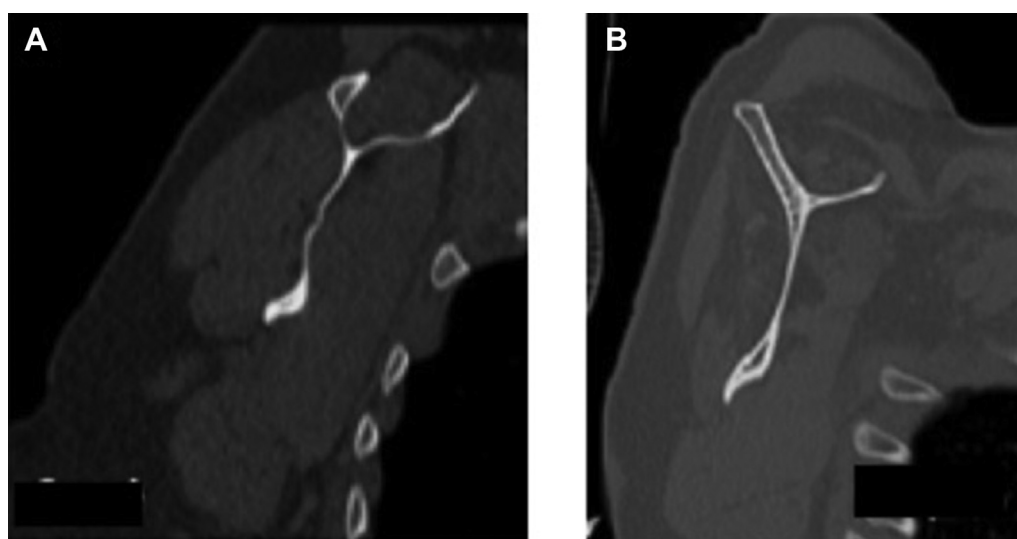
(A) Computed tomography scan showing teres minor fatty degeneration Goutallier grade 0: sagittal cut; (B) Fatty degeneration Goutallier grade 4: sagittal cut.
